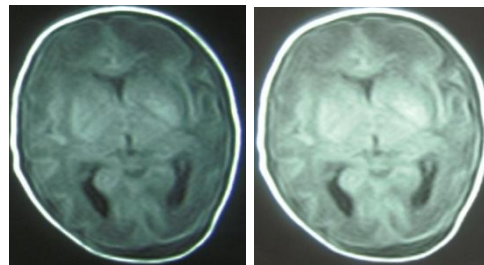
T1 and T2 FLAIR sequences of brain MRI of the patient (without Gad). There were no significant findings in these images.
